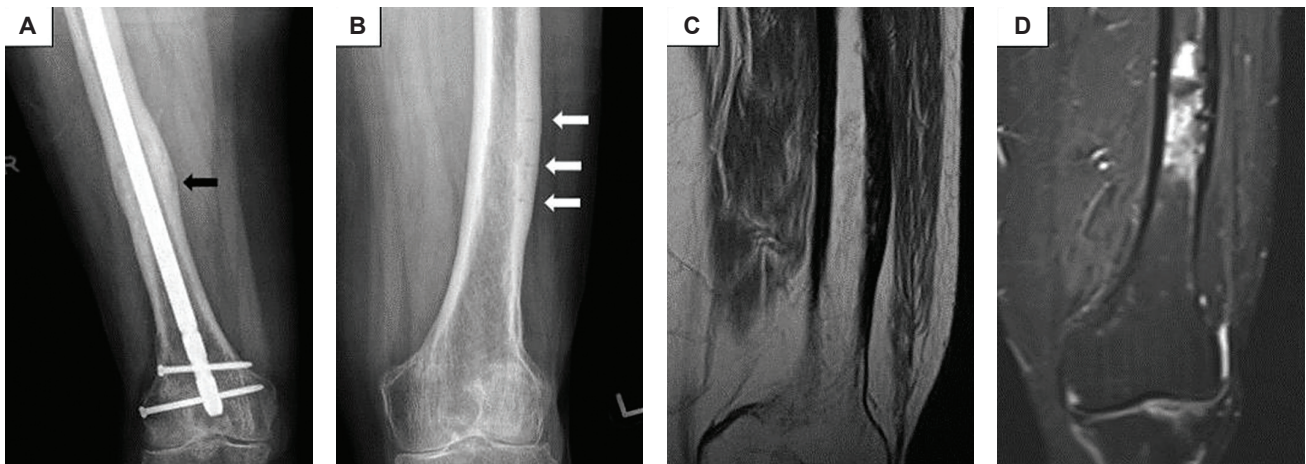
Radiographs and Magnetic resonance imaging (MRI) during follow-up visits in 2020 and 2022. (A) Radiograph of right femur at 10 months (2020) after surgery showing callus formation, progressive healing of right mid-shaft AFF (black arrow) and stable alignment of the IMN. (B) Radiograph of left femur taken in 2022 showed persistence of the transverse lucent lines and thickened lateral cortex (white arrows), suggestive of persistent incomplete AFFs. (C) Turbo spin-echo proton-density weighted (TSE PD) MRI of left thigh showing chronic periosteal thickening and cortical sclerosis of the lateral aspects of the distal femoral shaft while (D) Turbo inversion recovery magnitude (TIRM) MRI shows irregular intramedullary high fluid signal of the distal left femoral shaft adjacent to the area of chronic cortical sclerosis, likely reflecting areas of bone marrow oedema secondary to reparative process from atypical cortical stress fractures.
